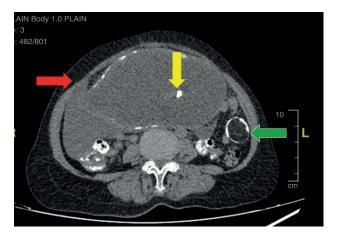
CT image of chronic mature cystic teratoma with focal defect on right lateral wall (red arrow) and collection of fluid adjacent to it. Presence of peritoneal nodule with calcified rim seen (green arrow) and single dentiform shaped calcification (yellow arrow).
